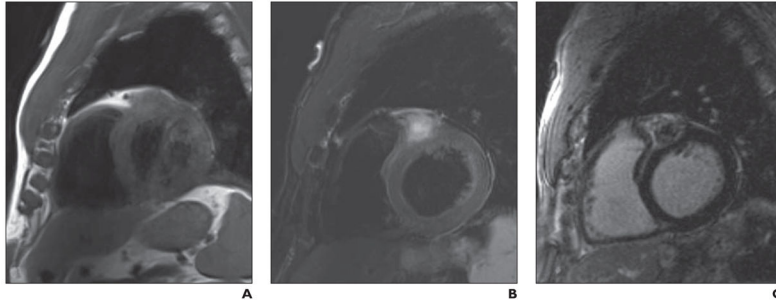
69-year-old man with history of melanoma and incidental discovery of atrioventricular groove mass on echocardiography
